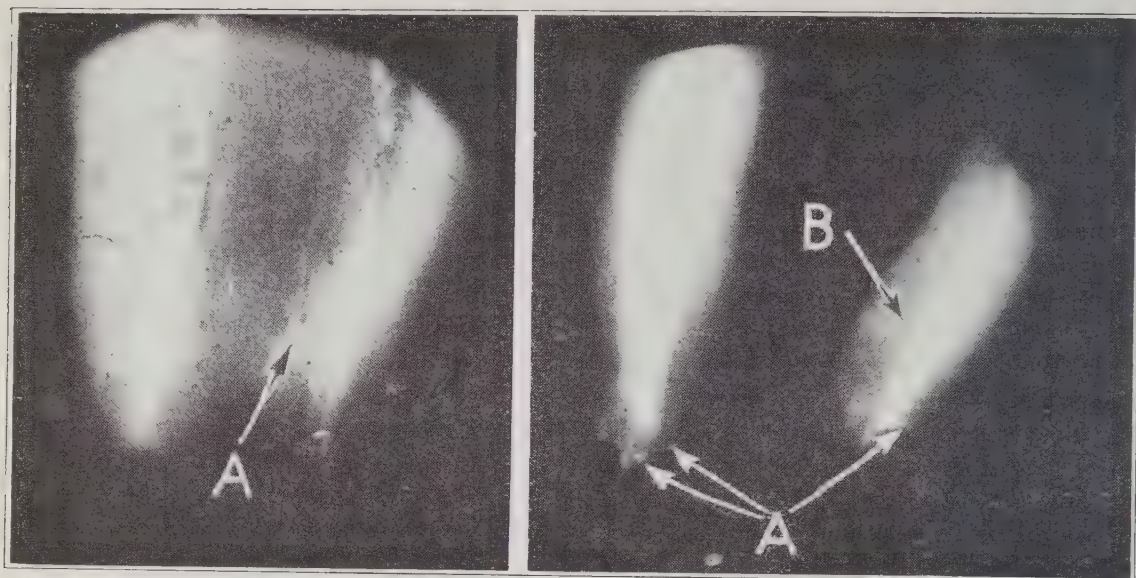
Enlargement of radiograph showing penetration of colloidal silver in root-canal of molar. The outline of the root-canals is very definitely shown together with the position of accessory foramina as indicated at A and B.
